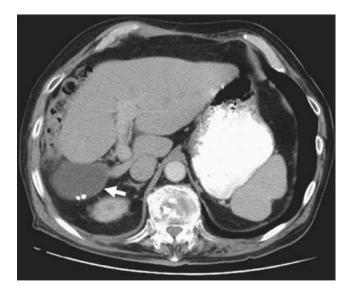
Computed tomography scan performed approximately 3 months prior to cholecystectomy. This demonstrates agenesis of the right liver and the unusual position of the gallbladder (*arrow*) on the underside of the hypertrophied left liver. The enlarged left portal vein and its unusual entry into the umbilical fissure from the left were confirmed.
